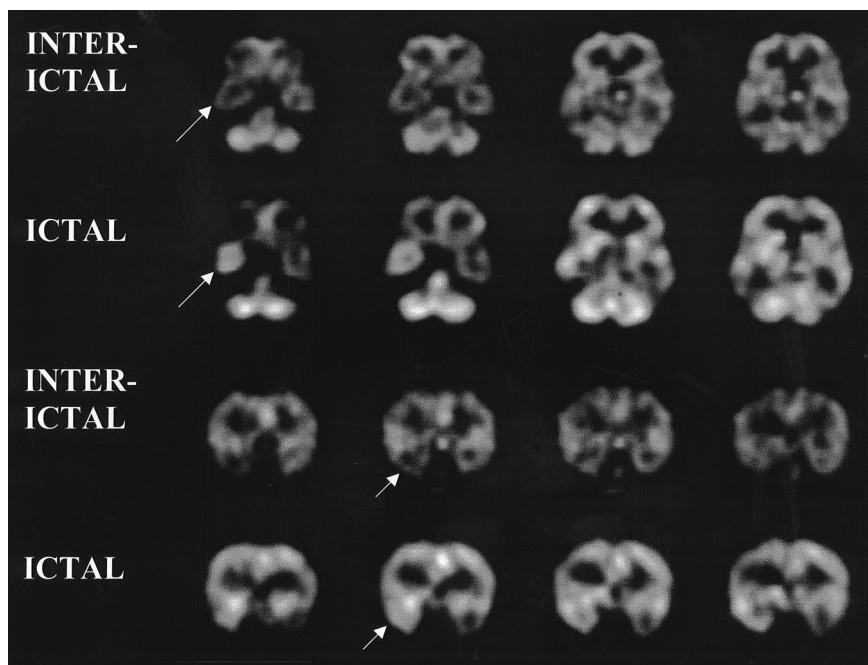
A 21-y-old left-handed man had history of tonic-clonic seizures since age 8. Head CT findings were normal. MRI showed T2-weighted hyperintense signal and slightly decreased size of right hippocampus. EEG showed acute waves in right frontal and temporal lobes. Interictal and ictal transaxial and coronal slices show hypoperfusion and hyperperfusion, respectively, of right temporal lobe (arrows).
